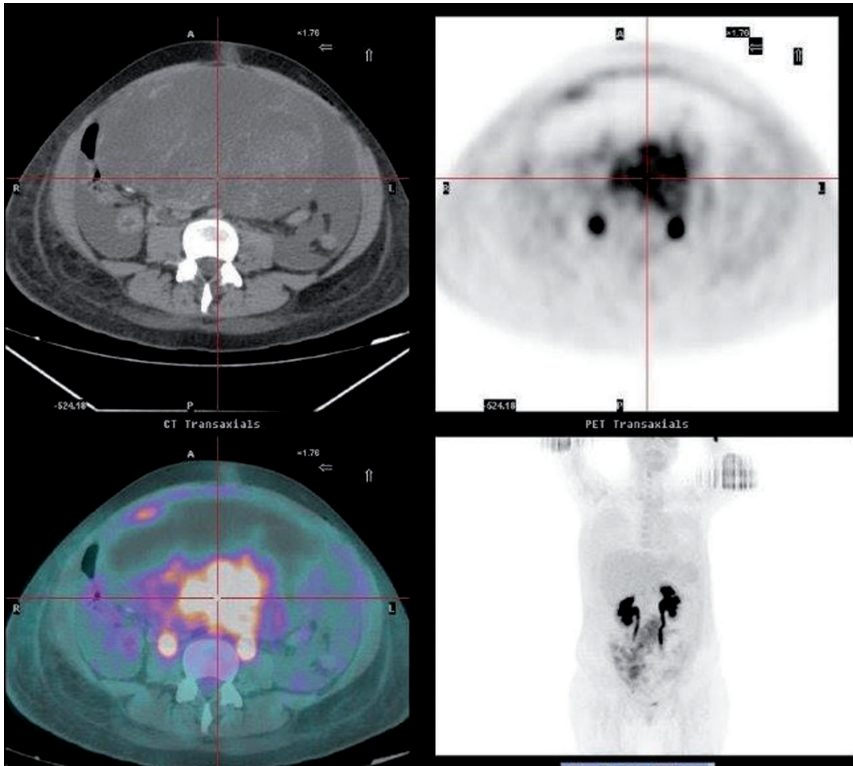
18F-FDG-PET and CT transaxial images showing the large pelvic mass with high metabolic activity (SUV 20.3), compressing the ureters.
